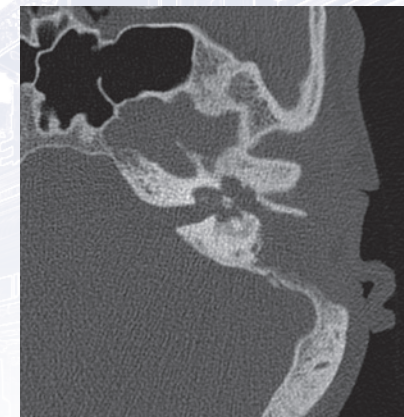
Axial CT temporal bone demonstrating erosion into the cochlea and vestibule with a completely opacified middle ear cleft and mastoid cavity.
